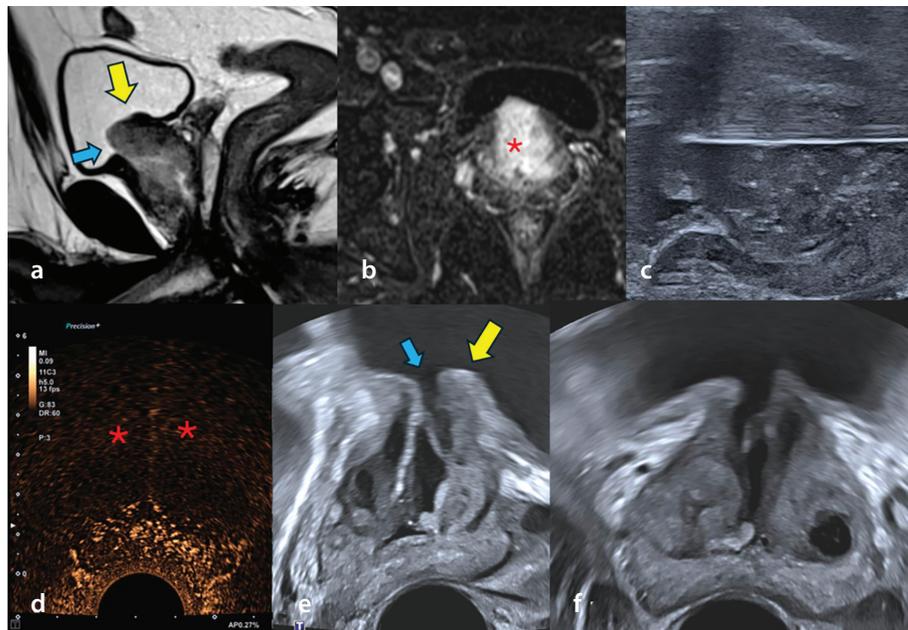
Patient with inadequate initial response requiring retreatment. (a, b) Multiparametric prostate magnetic resonance imaging at 6 months post-ablation, sagittal (a) and axial post-contrast (b), demonstrates an intravesical prostatic protrusion [intravesical prostatic protrusion (IPP), yellow arrow] measuring 12 mm, consistent with a possible valvular mechanism compressing the proximal urethral lumen (blue arrow). Hyperenhancement of the periurethral tissue and IPP is also noted (red asterisk). (c) Repeat transperineal radiofrequency ablation was performed with direct probe placement into the IPP and periurethral zone. (d) Immediate contrast-enhanced ultrasound confirmed devascularization of the transition zone and IPP. (e, f) Follow-up transrectal ultrasound at 30 days demonstrated marked IPP reduction, opening of the urethral channel, and likely resolution of the valvular mechanism. Clinically, International Prostate Symptom Score improved from 18 pre-retreatment to 2 at 30 days, with complete discontinuation of benign prostatic hyperplasia medications.
